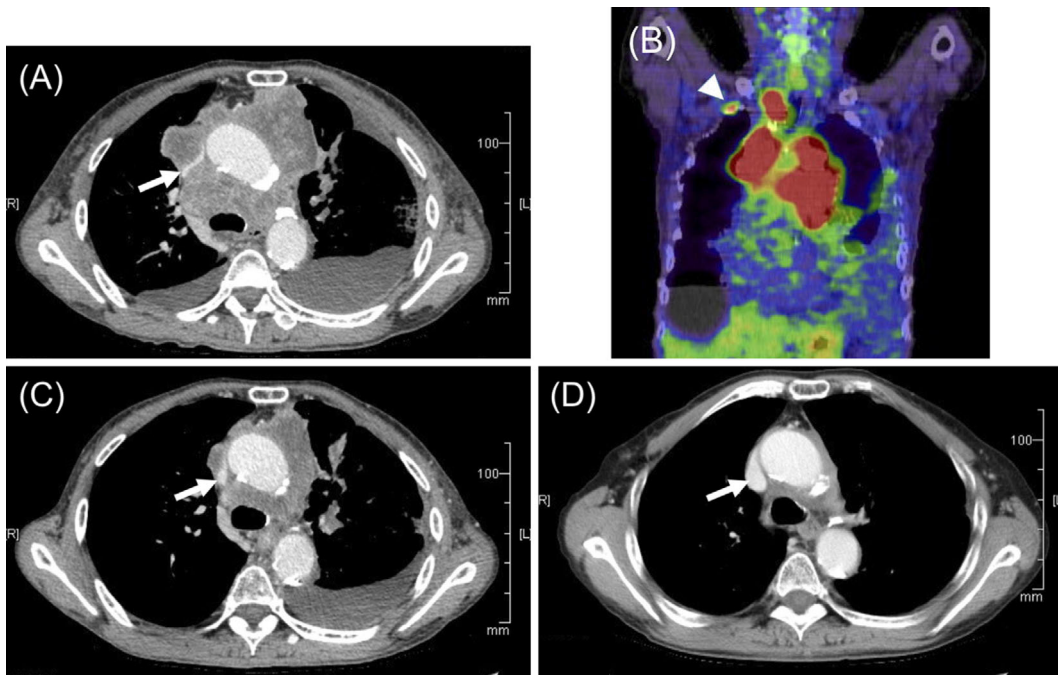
(A) Enhanced chest CT revealed a solid mass of 106 mm in diameter with severe obstruction of SVC (arrow) in anterior mediastinum. (B) Intense uptake ($SUV_{max}=16.9$) of the tumor and right supraclavicular lymph nodes (arrowhead) without any other evidence of metastasis on PET/CT. (C) Patency of SVC was restored after radiotherapy. The tumor was reduced to 73 mm. (D) Chemotherapy with cisplatin and etoposide resulted in complete response of the tumor. SVC: superior vena cava
